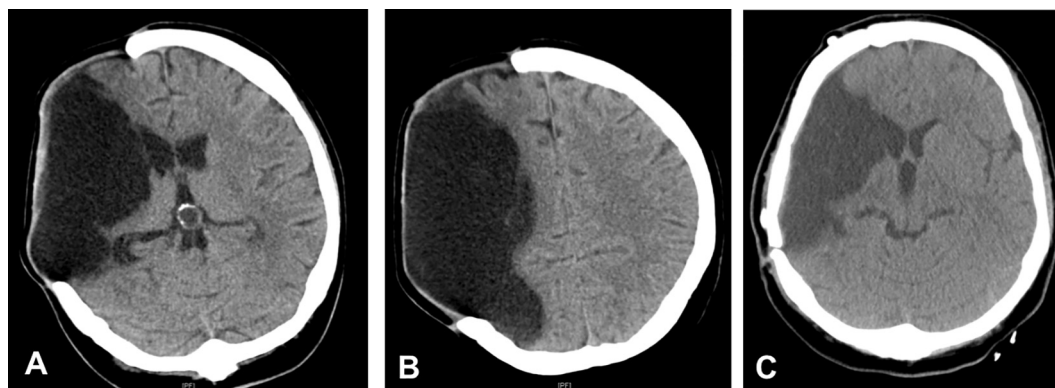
A + B: CT-scan of a female patient five month after an MCA-stroke and right-sided decompressive craniectomy. The cranial defect is raised over the bone margins and CP without drainage of CSF is not possible. C: CT-scan of the same patient one day after successful CP using the LD for CSF reduction.
